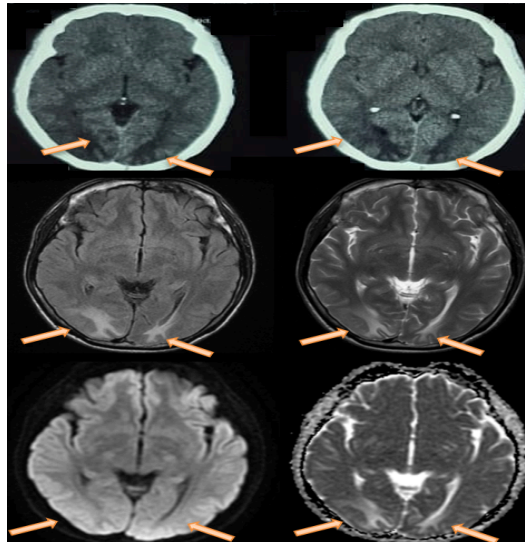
Neuroimaging reveals hypodense lesions with “finger-like appearance” in bilateral temporooccipital lobes suggestive of vasogenic edema on CT brain without contrast (top left and top right). MRI brain without contrast reveals, showing hyperintense lesions of bilateral occipital lobes without any mass effect or herniation on T2 FLAIR (mid left), T2 (mid right), DWI (bottom left) and ADC (bottom right) sequences, consistent with vasogenic edema and indicative of PRES.
